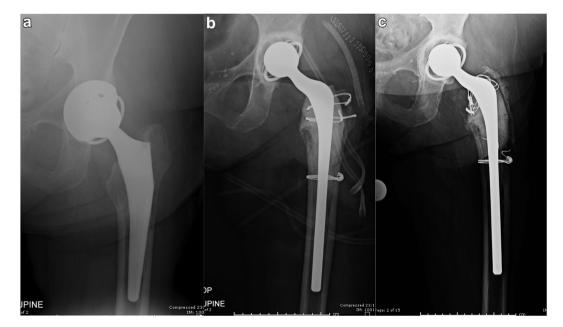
(a) AP radiograph of the left hip taken prior to first-stage revision total hip arthroplasty showing a constrained liner. (b) AP radiograph of the left hip taken immediately following first-stage revision, showing a constrained liner cemented in place. (c) AP radiograph of the left hip taken at 6-month follow-up. AP, anterior to posterior.
